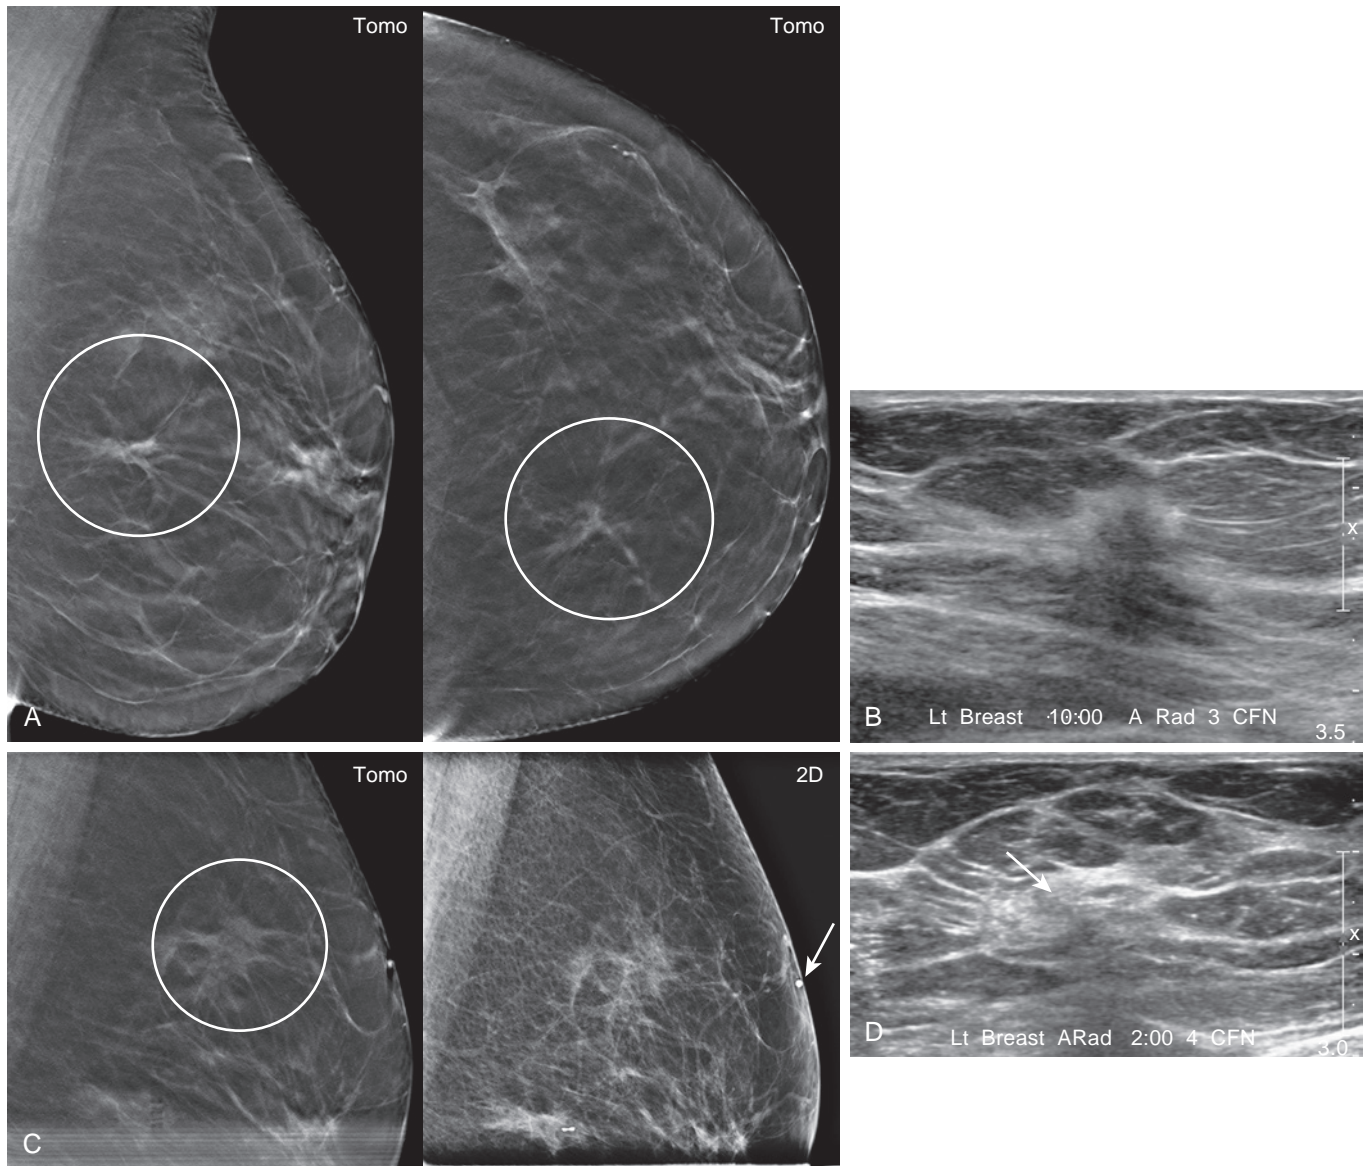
(A) A 64-year-old woman presented at another institution for screening mammography, which demonstrates architectural distortion (*circles*) in the upper-inner quadrant of the left breast, seen best on tomosynthesis views. (B) Targeted ultrasound reveals an 0.8-cm, irregular, hypoechoic mass with an echogenic rim in the 10-o'clock position, correlating with the mammographic findings. (C) On further review of the case prior to surgery a second architectural distortion (*circle*) was noted in the upper-outer aspect of the breast. (D) Targeted ultrasound of this area reveals a subtle, hypoechoic lesion at the 2-o'clock position, shown by BB (*arrow*) to correlate with the second lesion. Biopsy of both areas showed invasive lobular carcinoma. The patient underwent mastectomy, which showed 6.3 cm of disease, ER+/PR+/Her-, spanning both the upper-outer and upper-inner quadrants.
